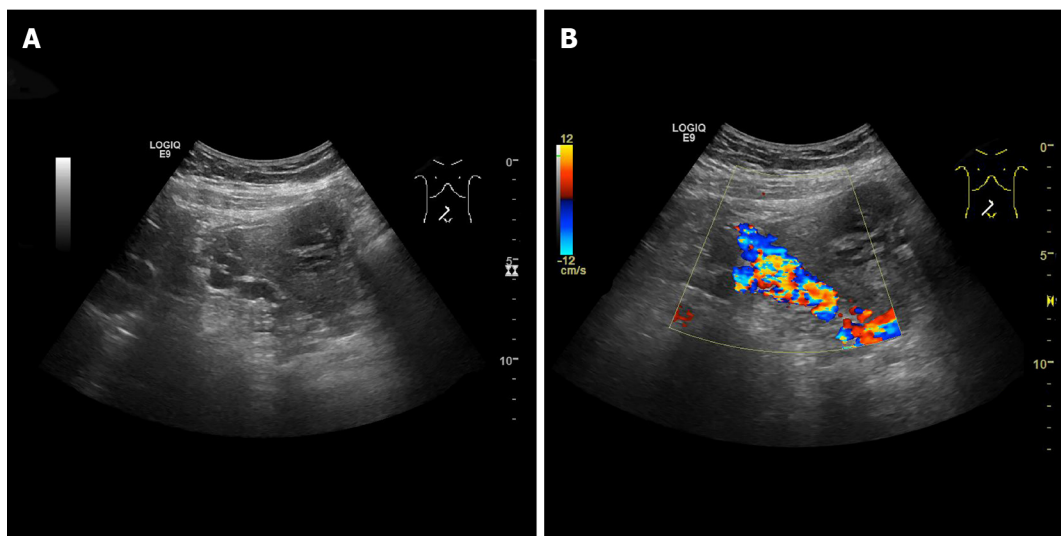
Color Doppler ultrasound images. A: Color Doppler ultrasound demonstrated many twisted tube-like echoes around the bladder; B: Color Doppler flow imaging showed color flow signal inside the tube-like echoes.
